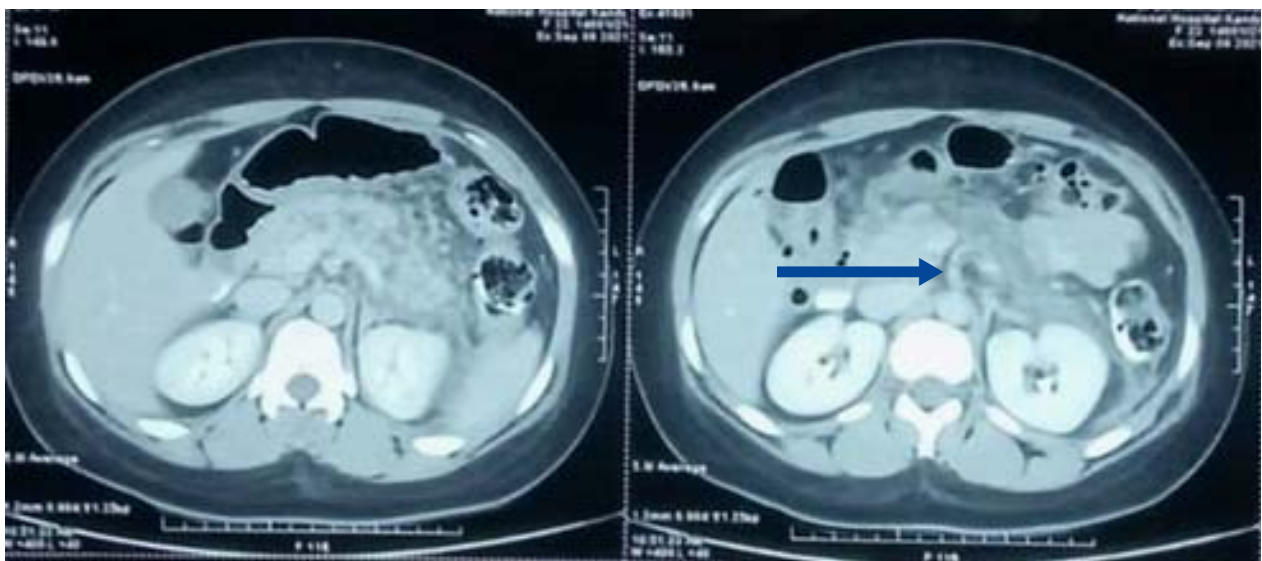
CT images depicting diffuse oedema of the pancreas, peri pancreatic fat stranding and areas of necrosis consistent with acute necrotizing pancreatitis.
